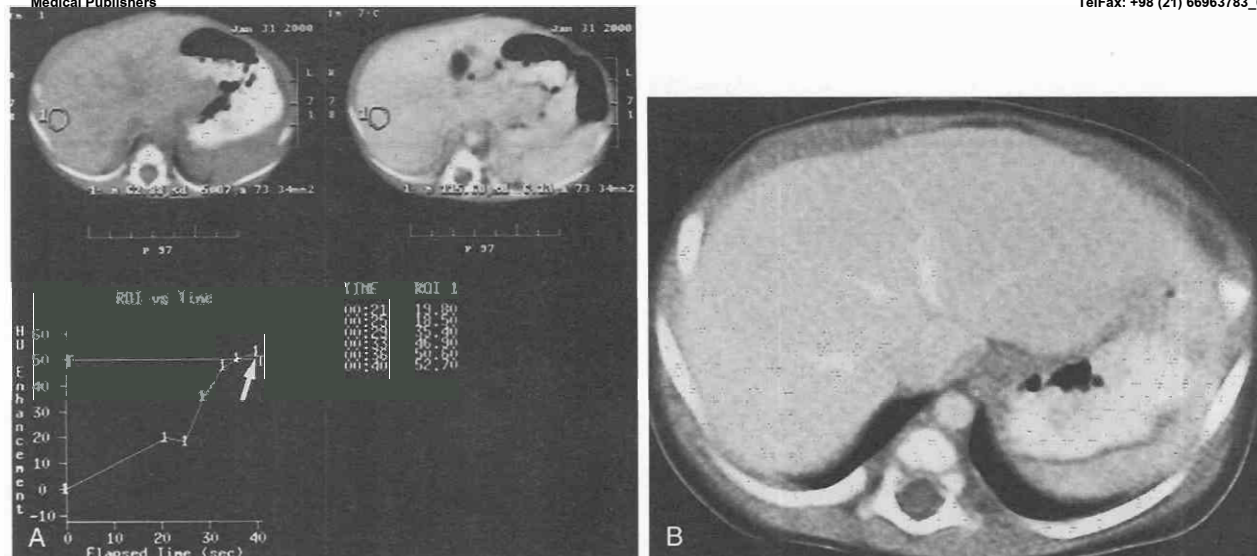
Value of bolus-tracking technology in a 14-day-old male infant. The rate of contrast administration (manual injection via a 24-gauge angiocatheter in the hand) was 0.25 mL/sec. A, Bolus-tracking technology displayed on the CT monitor includes the baseline unenhanced image of the liver (upper left), final image in the series (upper right), and graphic (lower left) and tabular (lower right) display of actual hepatic enhancement. A region-of-interest cursor was placed on the liver. Diagnostic scanning was initiated once hepatic enhancement surpassed 50 Hounsfield units (arrow). Each of the seven images obtained during bolus tracking (one baseline precontrast image and six postcontrast monitoring images) was obtained at 8 mA. B, Axial contrast-enhanced CT scan near the level of the confluence of the hepatic veins demonstrates excellent enhancement of the liver parenchyma, hepatic veins, and aorta.
